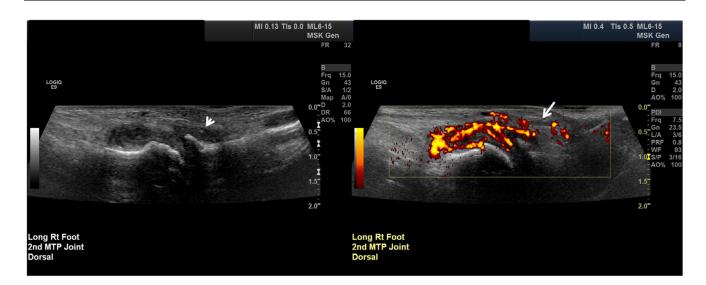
Grayscale and color Doppler sagittal images of the right foot second metatarsophalangeal joint demonstrates marked synovial hypertrophy (arrowhead) with associated significant hypervascularity on color Doppler analysis (arrow). These findings are consistent with active synovitis.
